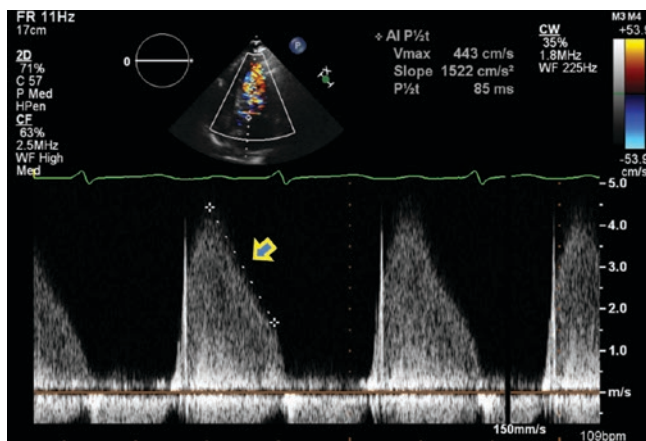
A well-defined Doppler envelope is demonstrated. The arrow points to the steep slope in severe acute aortic regurgitation. Pressure half time is 85 ms
